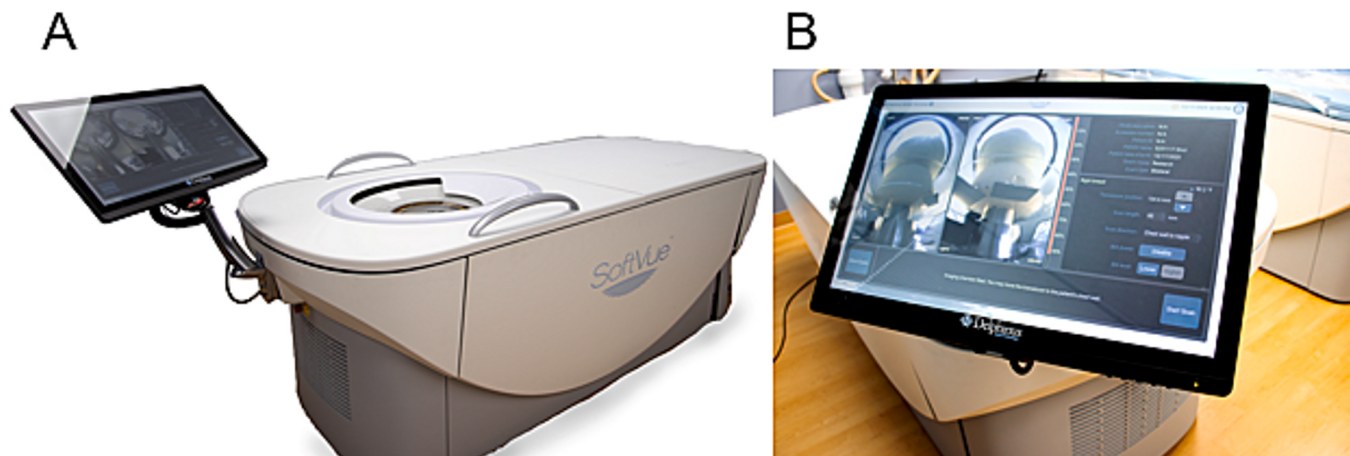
SoftVue Commercial Ultrasound Tomography Machine. (A) Photo of the SoftVue ultrasound tomography machine used to obtain images in this study. (B) Photo of the screen used to set machine settings with video of the water bath.
